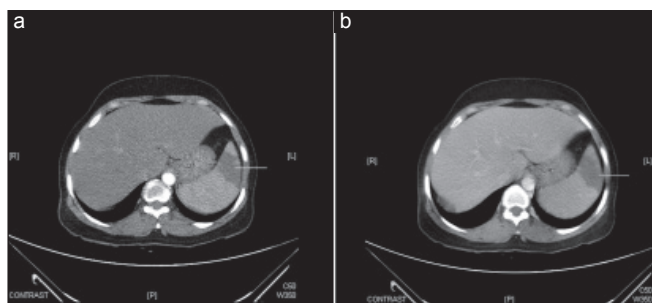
Computed tomography abdomen with contrast shows a well-defined non enhancing area in both arterial (a) and venous phases (b) measuring 4.4 cm × 3.3 cm × 6.5 cm in the anterior aspect of the upper pole of spleen with sharply demarcated margins-features suggestive of a splenic infarct
